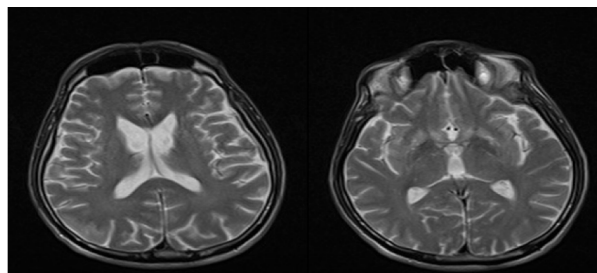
MRI show that putamen and caudat body atrophy.
